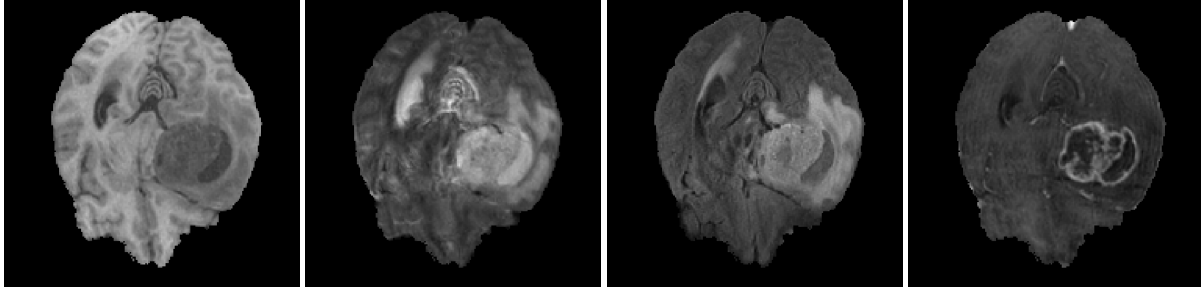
Four different structural MRI modalities from left to right: T1-weighted relaxation time, T2-weighted relaxation time, fluid-attenuated inversion recovery (FLAIR) scan and T1Gd-weighted scan with contrast agent gadolinium.
